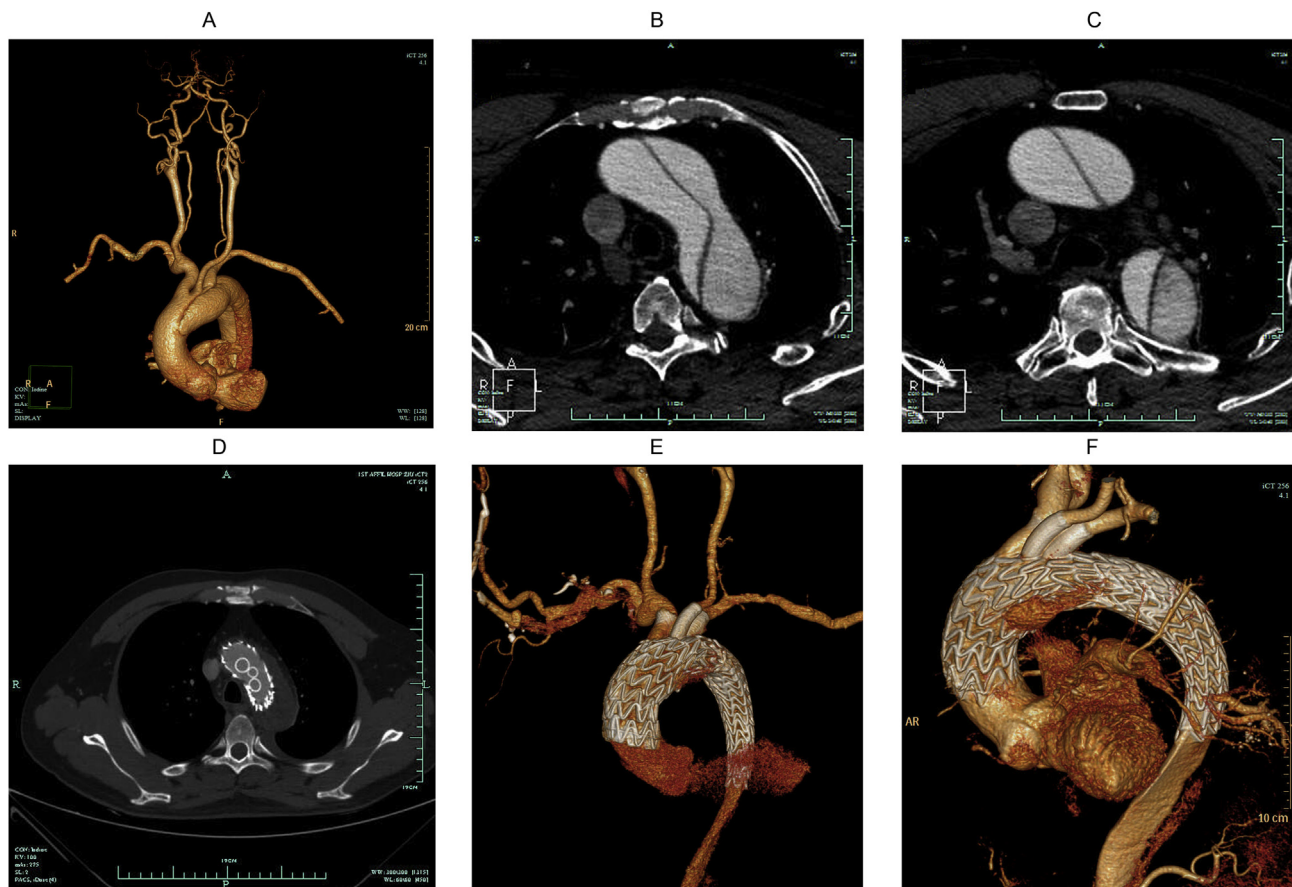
Pre-/post operation CTA images of a typical patient who underwent ETAAR via needle based ISF. (A) CTA shows a RAAD involving the aortic arch with the entry tear in the descending aorta. (B) and (C) Cross CTA shows the lesion involving Zone 0 to Zone 3. (D) and (E) 1 month post-operative CTA shows favourable seal of false lumen and patent supra-arch branch vessels. (F) 6 month post-operative CTA demonstrates stable and patent endografts with no endoleak. ETAAR = endovascular total aortic arch repair; ISF = in situ fenestration; CTA = computed tomography angiography; RAAD = retrograde type A aortic dissection.
